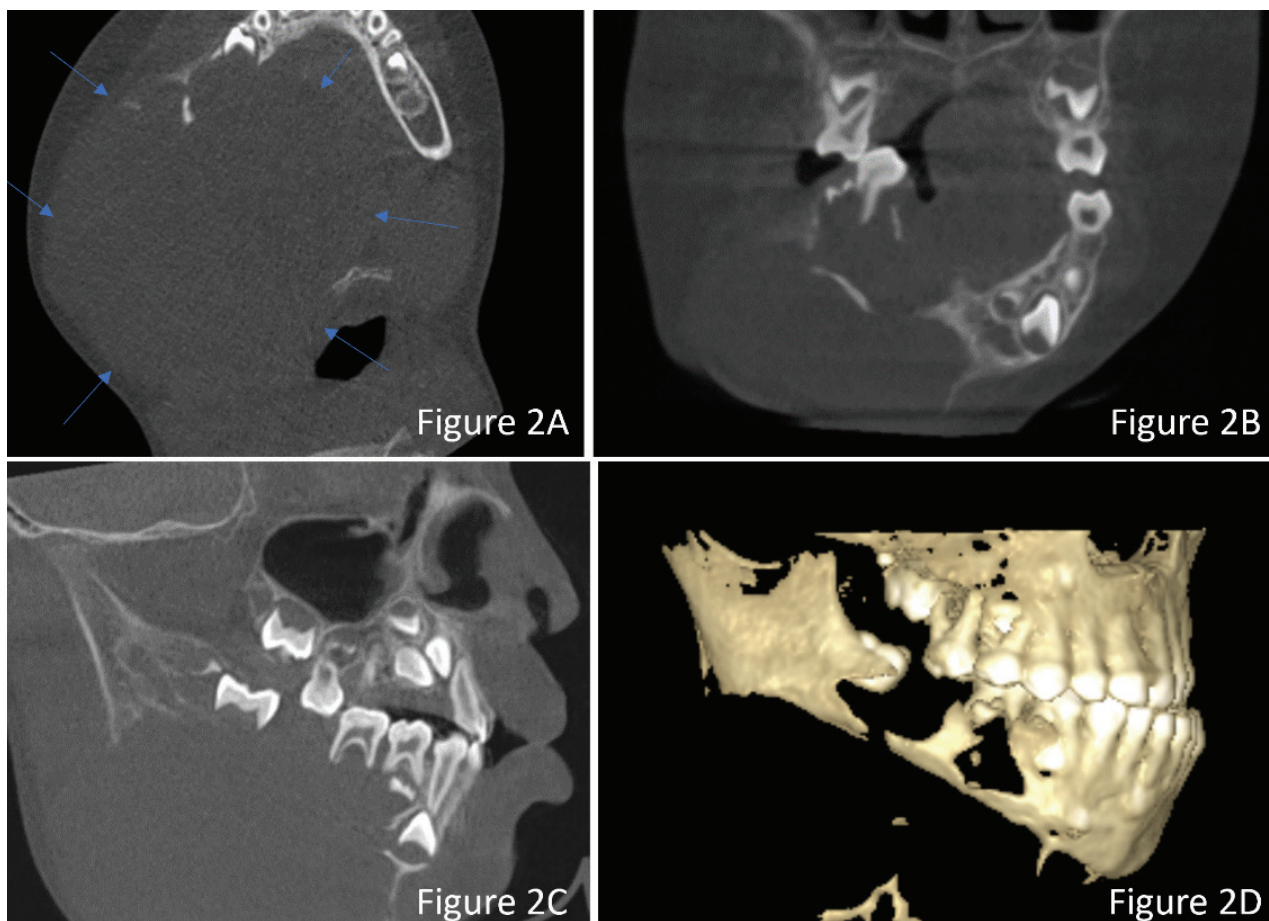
CBCT multiplanar reformatting showing the lesion in the right mandible with expansion, cortical perforation and destruction throughout the entire lesion, extending posteriorly into the corpus, angle and ramus but excluding the condyle and coronoid. (A) Axial view of the lesion with the blue arrows indicating the margins of the lesion. (B) Coronal, (C) sagittal and (D) three-dimensional reconstruction of the lesion indicating the extent of destruction.
